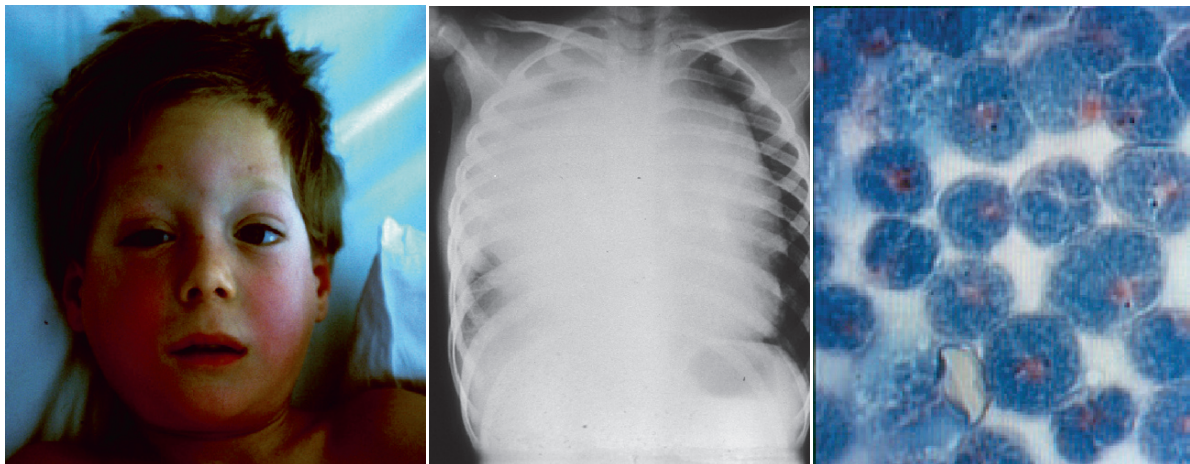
Five year old boy, who had clinical examination because of abdominal pain and distention. Ultrasonography and MRI showed massive thickening of the bowel walls with some small areas of ascites between. Fine needle aspiration showed
